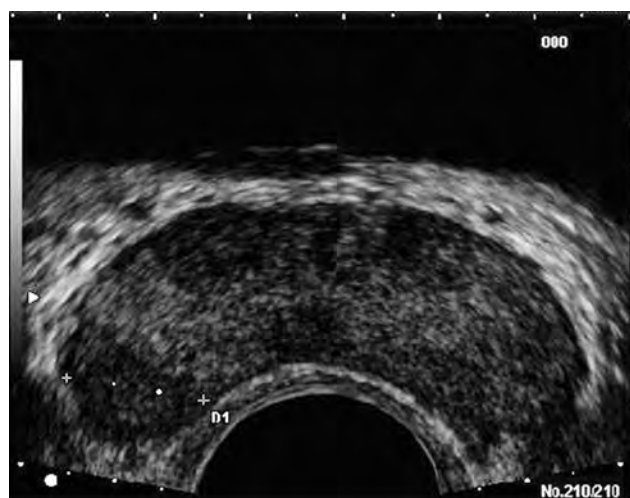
Classic hypoechoic peripheral zone lesion (dotted line between calipers) in the right mid-gland that transrectal ultrasound-guided biopsy proved to be a Gleason 3 + 3 = 6 adenocarcinoma.
